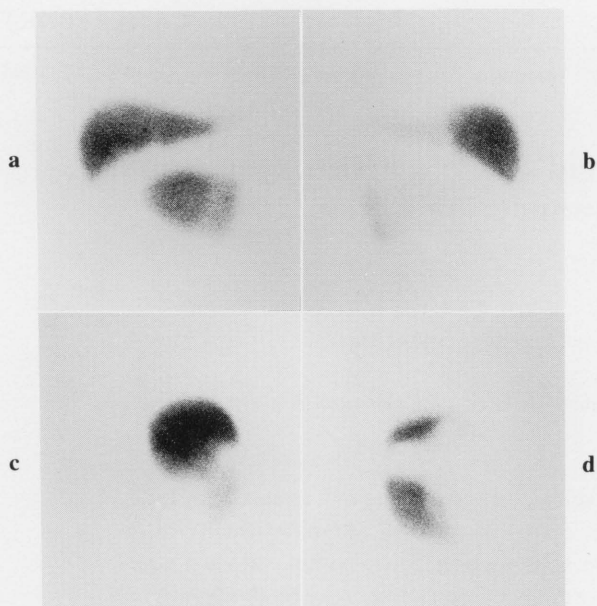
The anterior (a), posterior (b), right lateral (c) and left lateral (d) views, respectively. The first ^{99m}Tc -Sn-colloid scintigraphy reveals marked splenomegaly with the spleen located lower than in the left upper quadrant.
